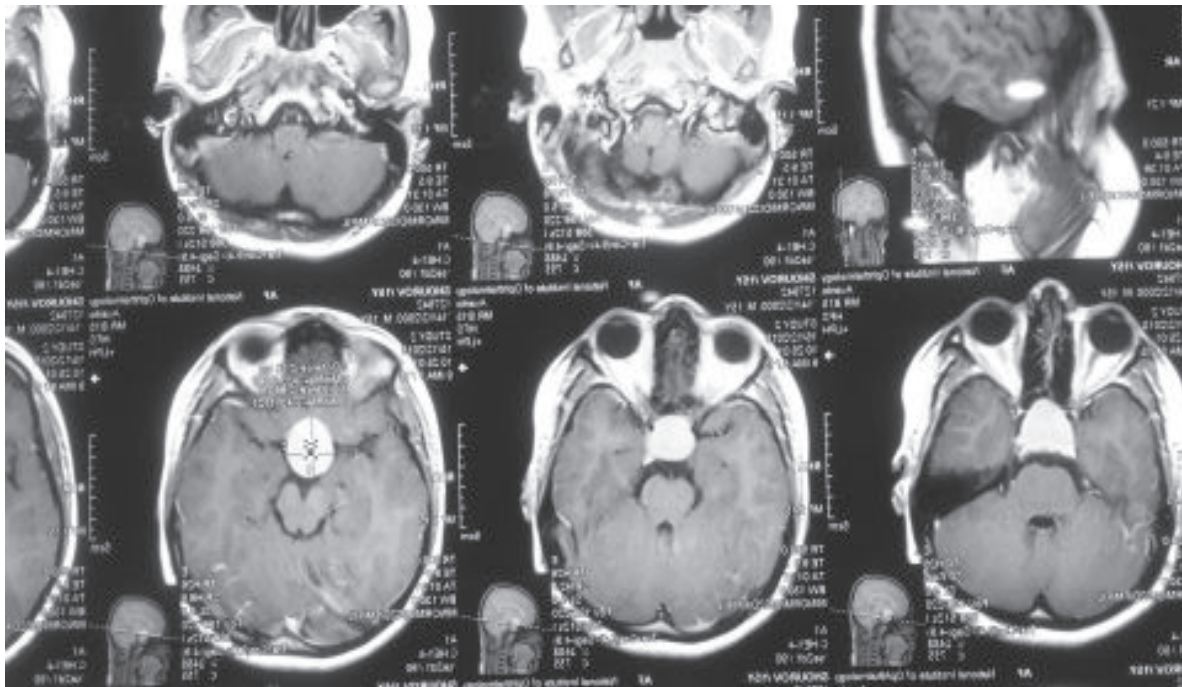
Preoperative MRI show macroadenoma (Axial)
